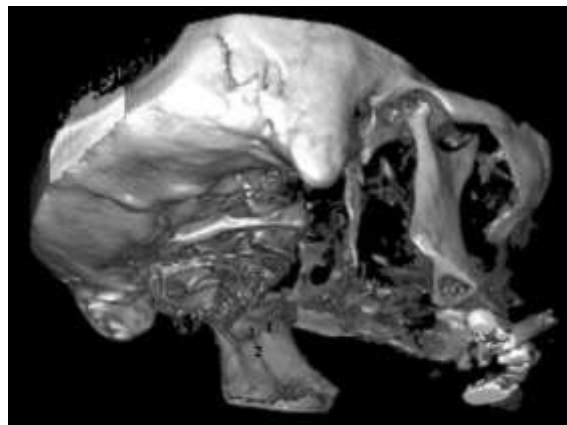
Mandibular foramen and surrounding anatomical landmarks. 54 aged woman. CT reconstruction.
